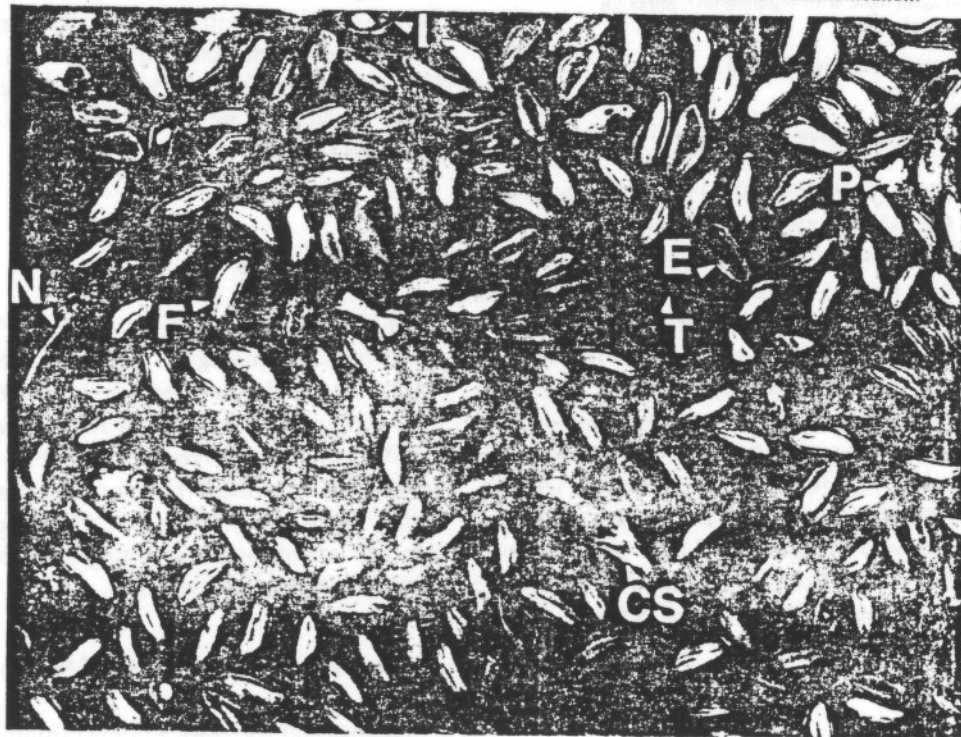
An x-ray radiograph of a typical mixture of filled seeds (F), empty seeds (E), seeds containing an insect larvae (I), and some inert matter such as a needle (N), twig fragment (T), pitch (P) and cone scales (CS). *Abies amabilis* (approx. life size).
